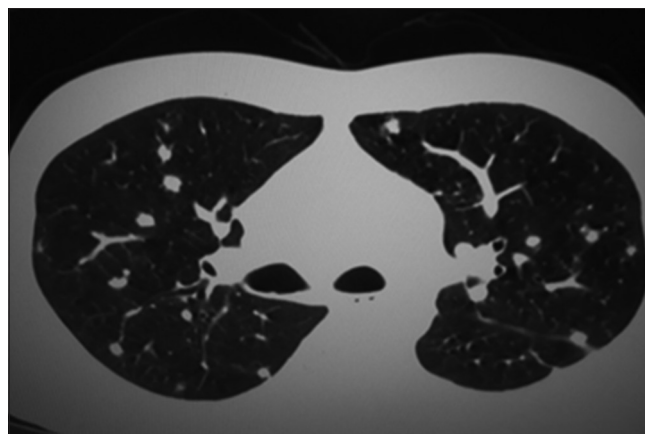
Computed tomography thorax lung window image showing multiple nodules in both lungs
